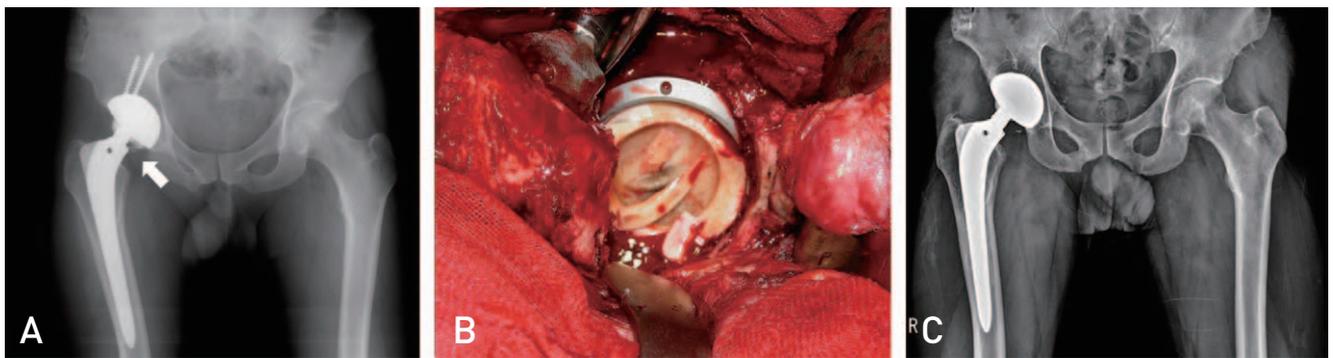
(A) Anteroposterior radiograph of pelvis (patient 1) shows fractured ceramic particles (arrow). (B) Intraoperative photograph shows fractured ceramic liner. (C) Radiograph taken 9 years after revision surgery shows no osteolysis or implant loosening.
